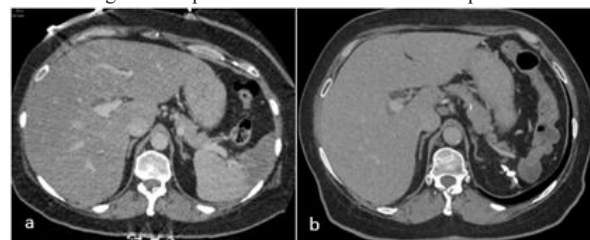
(a) Axial post-contrast CT in portal venous phase done 11 years ago shows wedge-shaped hypodensity involving the anterior pole of the spleen, consistent with a splenic infarct. (b) Follow-up axial post-contrast CT reveals post-splenectomy status with surgical clips seen
